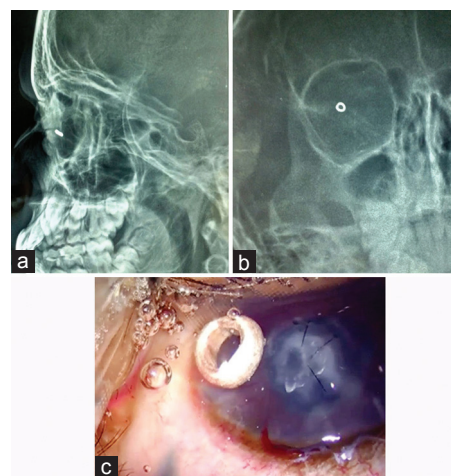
Lateral (a) and anteroposterior (b) radiographs demonstrate a ring-shaped foreign body located in the anterior orbit. (c) Ring-shaped foreign body removed from the cataractous lens.
